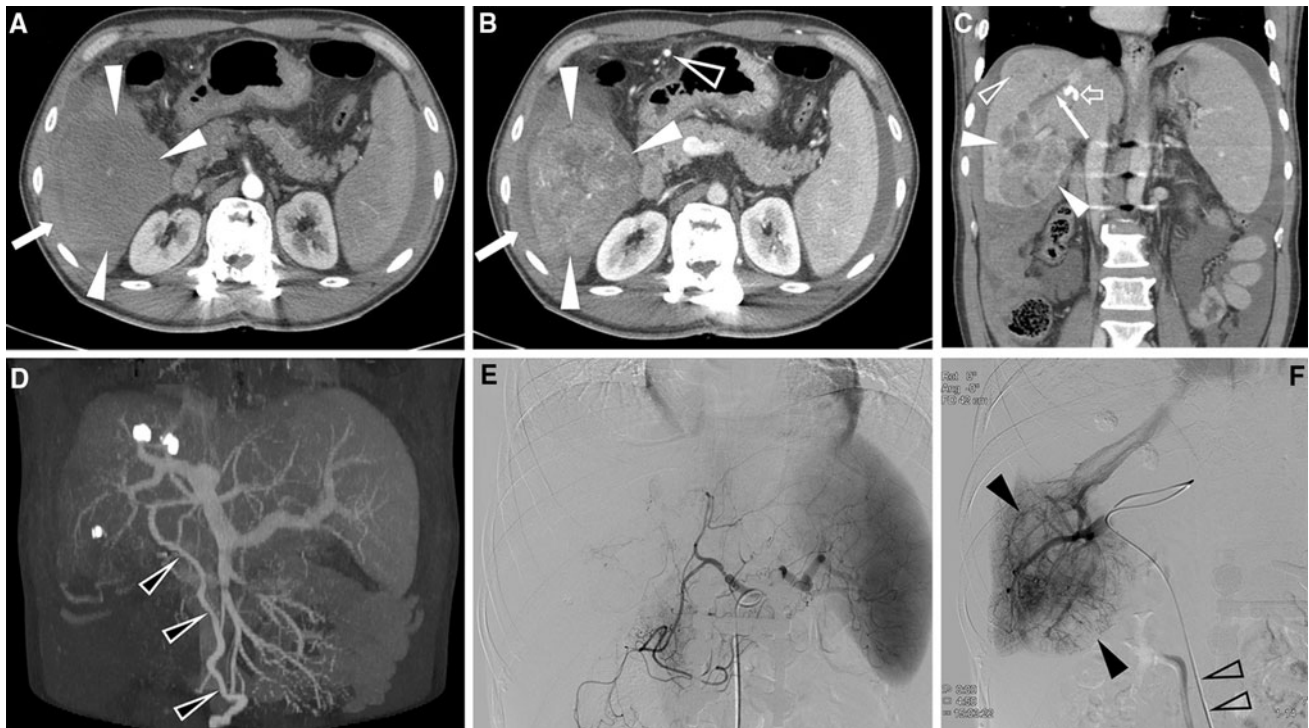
A case of a 45-year-old man with a ruptured HCC supplied by the portal vein is presented. A A transverse hepatic arterial phase CT scan shows a hematoma (*arrow*) of high attenuation around the liver, and a large mass (*arrowheads*) of low attenuation in segment VI of the liver. Note ascites of low attenuation around the spleen. B A transverse portal venous phase CT scan demonstrates a large mass (*arrowheads*) of heterogeneous high attenuation. Note the dilated enhancing paraumbilical vein (*open arrowhead*) and hematoma (*arrow*) around the liver. C A coronal delayed-phase CT scan shows a large low attenuating mass (*arrowheads*) in segment VI with a tumor thrombus (*arrow*) in the right hepatic vein. Note another small
